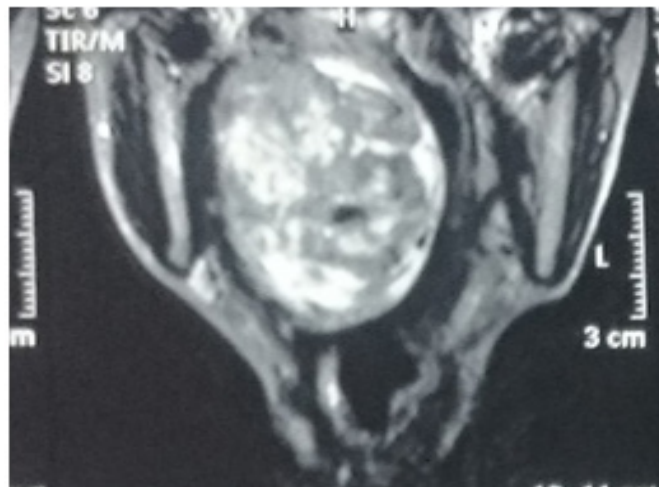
MRI showing right parapharyngeal mass
